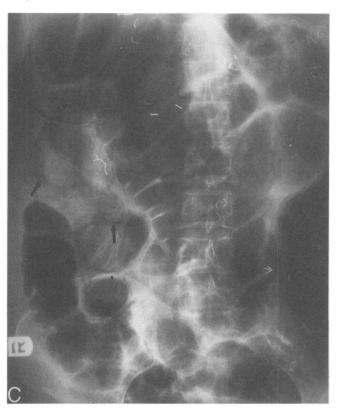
Plain film 2 weeks later again shows pneumatosis (3+) associated with gross ileus but no other significant complaints. The patient was discharged without further surgery.
